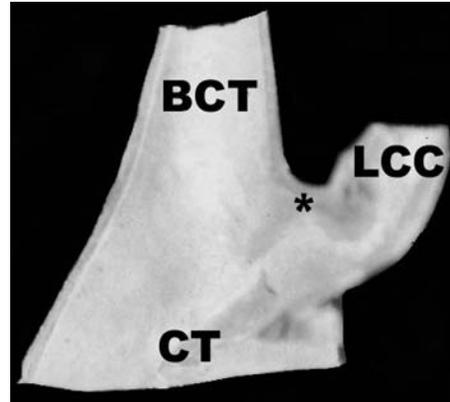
Coronal section of the common trunk (CT). It is observed how the LCC artery arises from the medial edge of the BCT. The ram (*) of separation is elevated to the plane of the single ostium.
